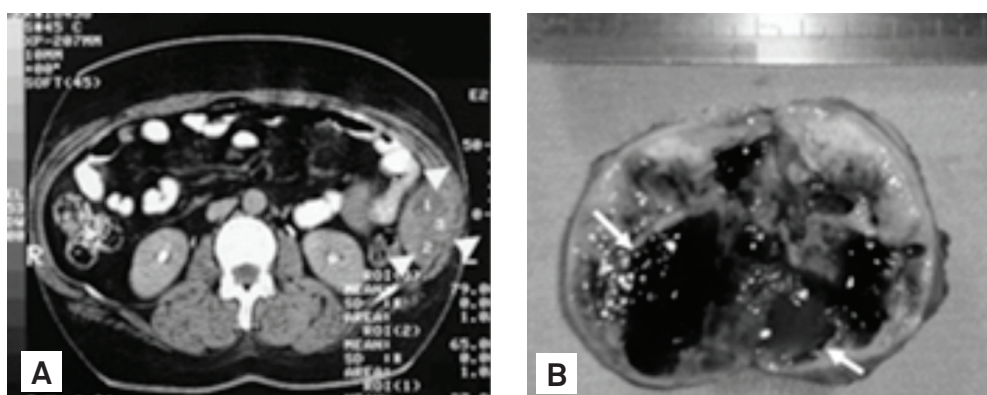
Subcostal schwannoma. (A) Computed tomography scan slice showing oval lesion (arrowheads) with definite and regular edges with broad base in the abdominal wall of the left flank; (B) The cut surface containing cystic areas with mucous content (arrows).
